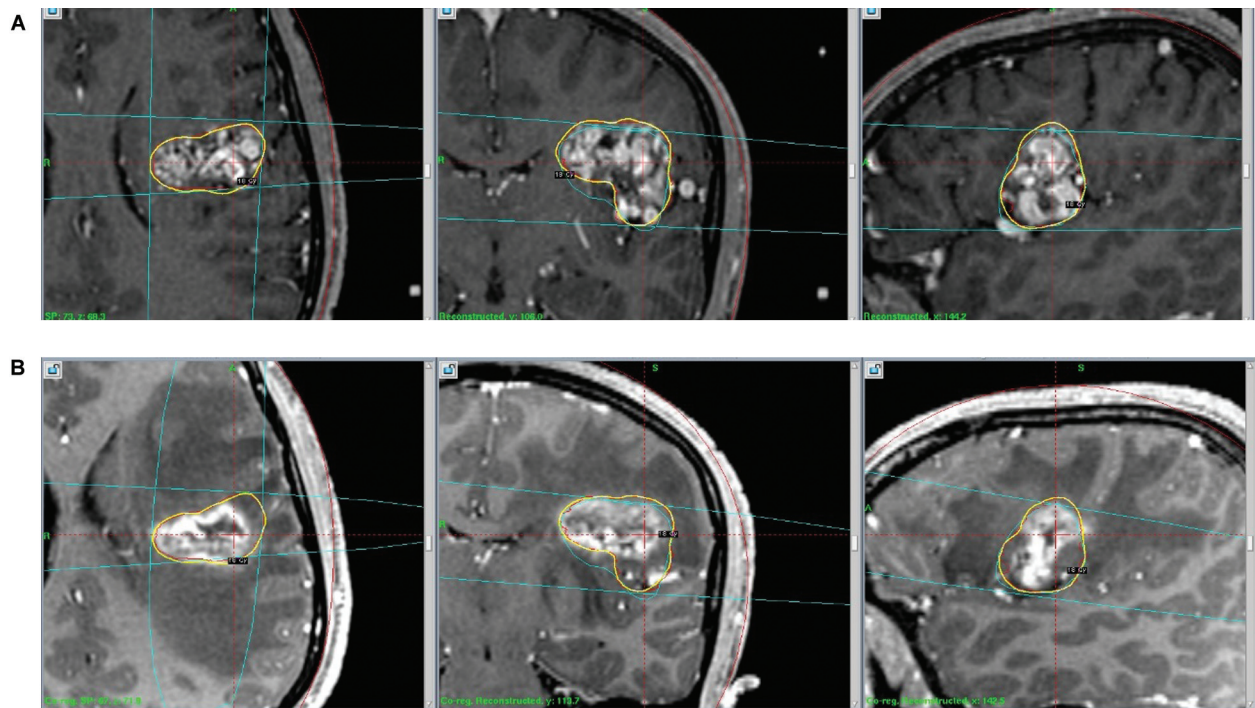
(A) Axial, coronal, and sagittal contrast-enhanced magnetic resonance imaging (CEMRI) brain of 8 years old child presented with headache and underwent gamma knife radiosurgery (GKRS) with margin dose of 18 Gy and volume of nidus 9 mL. (B) The follow-up scan at 1 year shows significant edema with radiation-induced change (RIC) and was managed with steroids.
